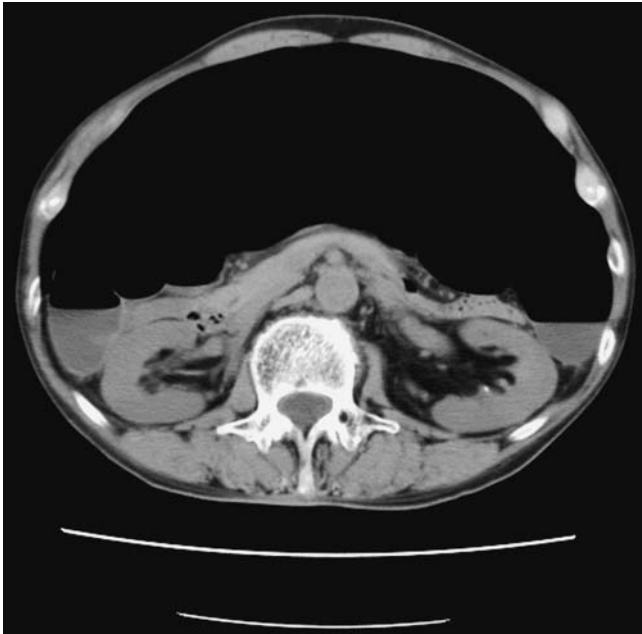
Abdominal computed tomography showed a large pneumoperitoneum causing collapse of the inferior vena cava.
